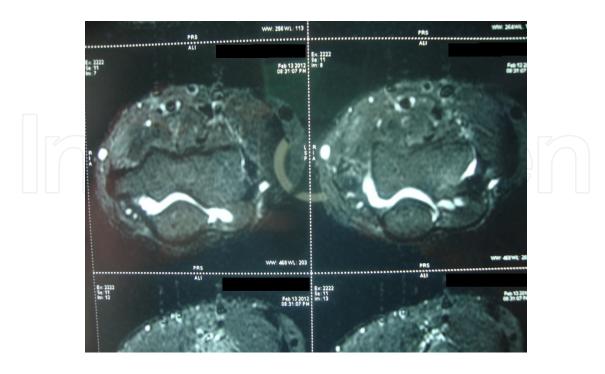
Axial section T2 MRI- showing LUCL tear
